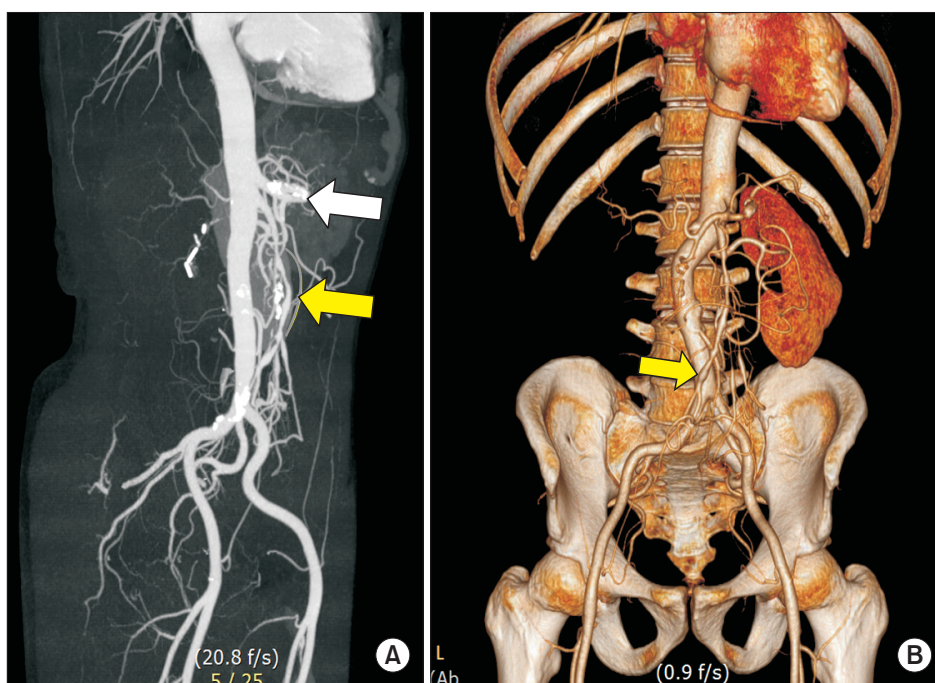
Follow-up computed tomography angiography 14 months later: the white arrow indicates a calcified splenic artery aneurysm. The line and gray arrow indicate the reconstructed superior mesenteric artery with a vein graft in 3-dimensional reconstruction (A). The arrow indicates another distal aneurysmal change (B).
